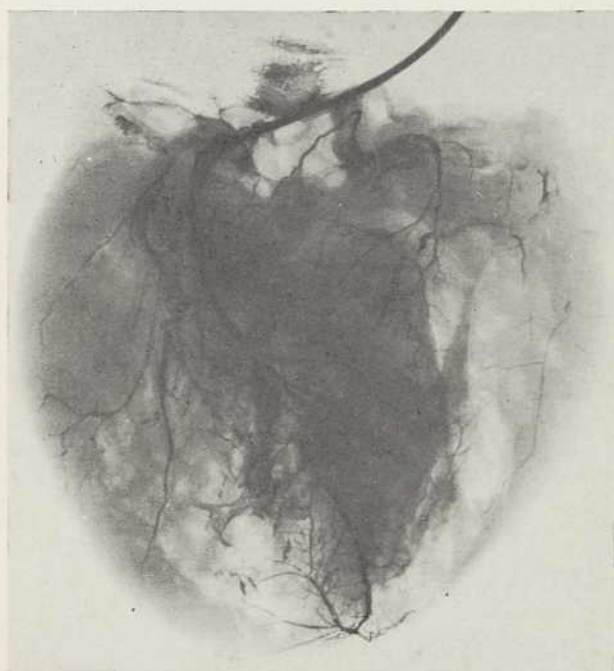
Radiographie de la pièce après injection des artères coronaires: l'artère circonflexe est thrombosée; l'artère interventriculaire antérieure présente plusieurs sténoses étagées, puis une thrombose. L'artère coronaire droite est interrompue par une thrombose à trois centimètres de son origine.
